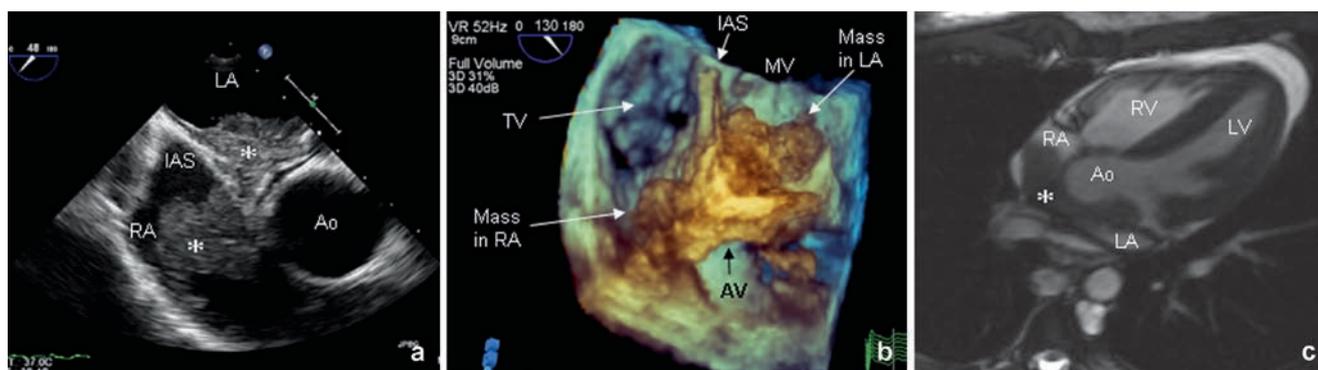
Highly malignant, cerebellary non-Hodgkin lymphoma in a 19-year-old male patient with secondary cardiac lymphoma manifestation in both atria. Trans-oesophageal echocardiographic imaging shows growth of lymphoma masses (*asterisks*) of heterogeneous texture on both sides of the inter-atrial septum (IAS) (a). Real-time 3D echocardiography (b) provides greater information on the location and extent of lymphoma manifestation. Cardiac MR
